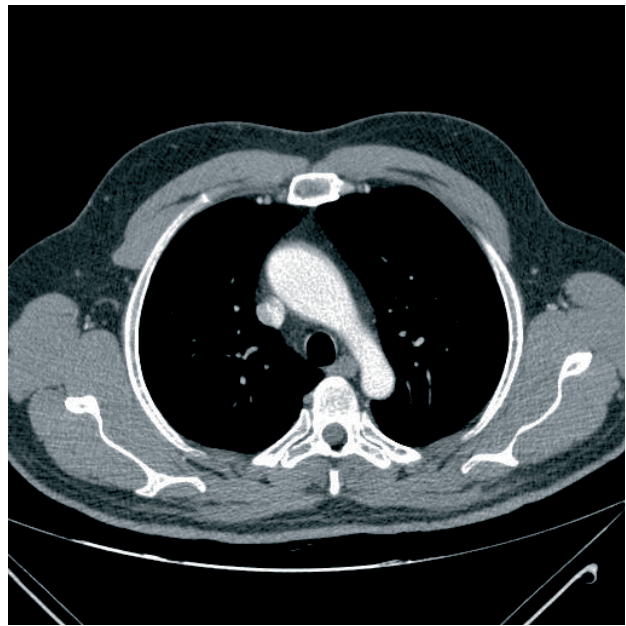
Contrast-enhanced chest CT scan, showing aneurysmal dilation of the ascending thoracic aorta (anteroposterior diameter, 44 mm), and a caliber change in the region of the aortic arch with diameter of 18 mm, and descending aorta of 22 mm.
